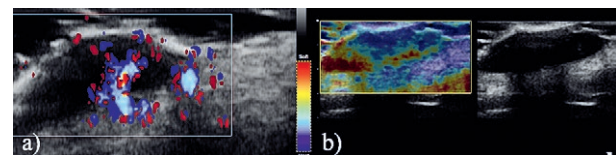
Cutaneous melanoma localized on the right mammary region, hypervascularized on Doppler US (a) and with stiff appearance on SE (b) in a 52 year old female. Breslow index 2.68 mm, thickness of the skin tumor measured by a 40 MHz frequency linear transducer was 2.55 mm.
